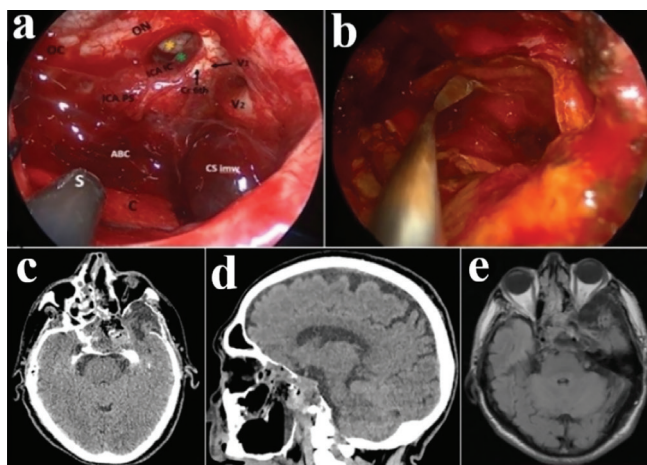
(a) Intraoperative endoscopic view. All neurovascular structures are visible because of bony dehiscence. OC=optic chiasm, ON=left optic nerve, ICA-PS=left parasellar carotid artery, ICA-IC=intracavernous horizontal segment of the left carotid artery, V1=left ophthalmic nerve, Cr 6th=left sixth cranial nerve, V2=left maxillary nerve, CS imw=inferior part of the medial wall of the left cavernous sinus, yellow asterisk=the base of the left anterior clinoid process, green asterisk=left third cranial nerve, C=cottonoid, S=suction. (b) Placement of the fascia lata in on-lay fashion. Axial (c), sagittal (d) CT scans obtained in the early postoperative period, and axial,T2-W MRI (e) obtained one year postoperatively showing acceptable outcome of skull base reconstruction
